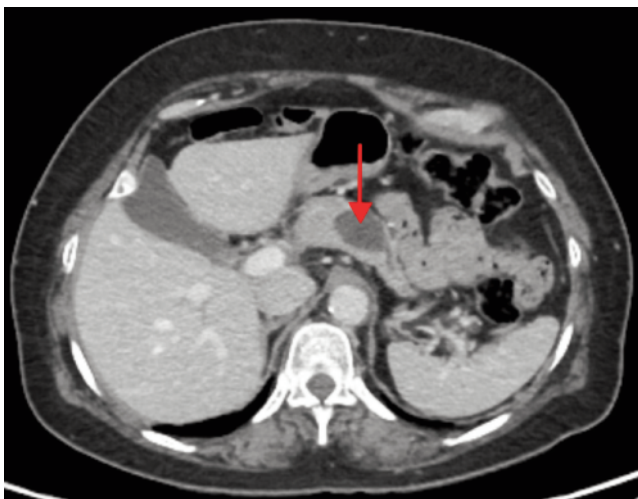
CT scan of abdomen transverse section (red arrow): a cystic pancreatic body mass.
